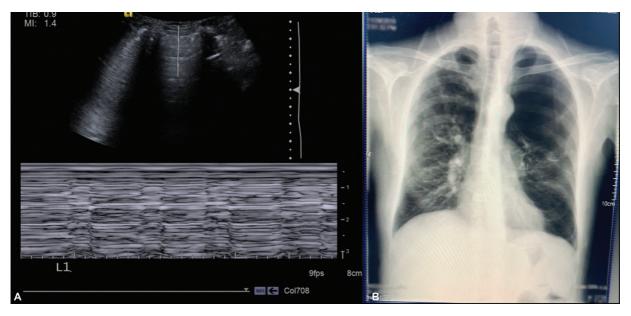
(A): Longitudinal gray-scale ultrasound scan of the left anterior chest along the midclavicular line, in the left second intercostal space, in a 60-year-old afebrile male patient presenting with dyspnea and cough revealed A-lines with absent lung sliding. Pneumothorax was suspected on the basis of ultrasound findings. However, Chest X-ray revealed (B) a large bulla in the left upper and mid zones. The final clinical diagnosis of the patient at the time of discharge was acute exacerbation of COPD.
